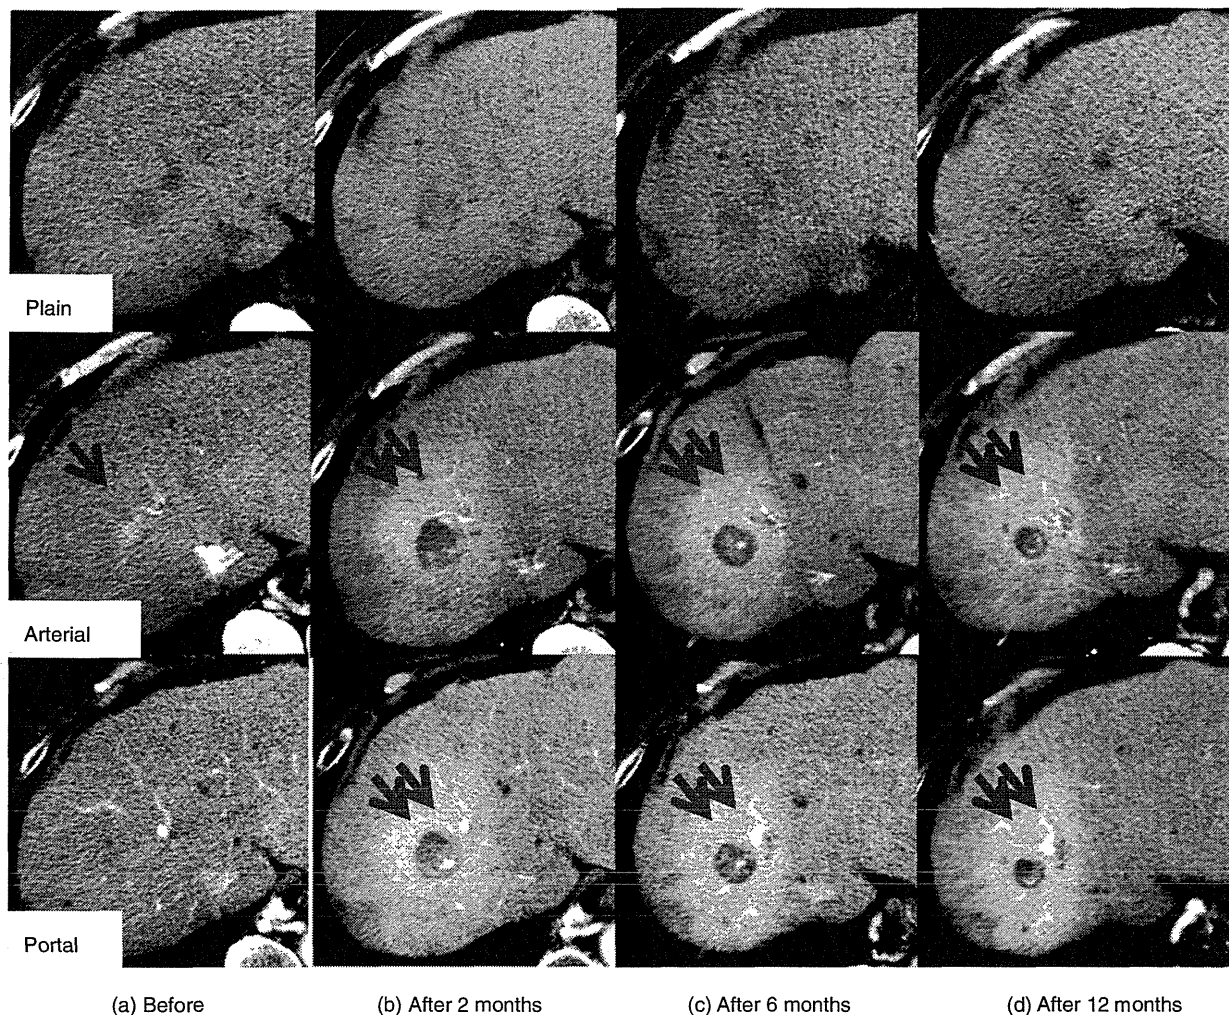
Dynamic computed tomography appearance of tumor response type 4 (plain, arterial and portal phase in case 11). (a) Before stereotactic body radiation therapy (SBRT), early arterial enhancement is visible (red arrow). (b) Two, (c) 6 and (d) 12 months after SBRT, hypodensity of the tumor changed and the tumor shrank without early arterial enhancement in arterial and portal phase (two red arrows). Radiation-induced liver damage is visible around the tumor.
